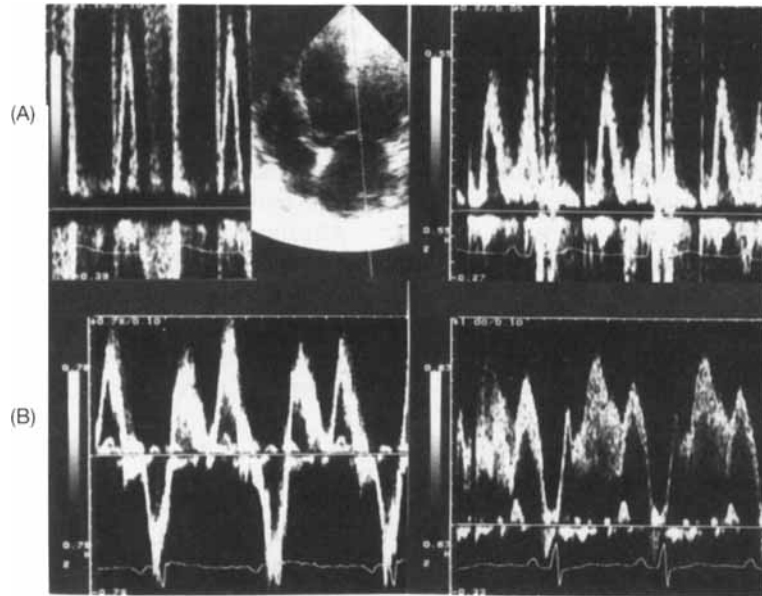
Pulsed-wave Doppler transthoracic (A) and transesophageal (B) recording before (1) and after (2) surgery in a patient with acute severe aortic regurgitation. Notice the absence of an A wave in the left ventricular inflow velocity recording (1A) and the presence of a large Ai wave in the pulmonary venous flow (1B). After surgery, the left ventricular inflow and pulmonary venous flow patterns become normal (2).
